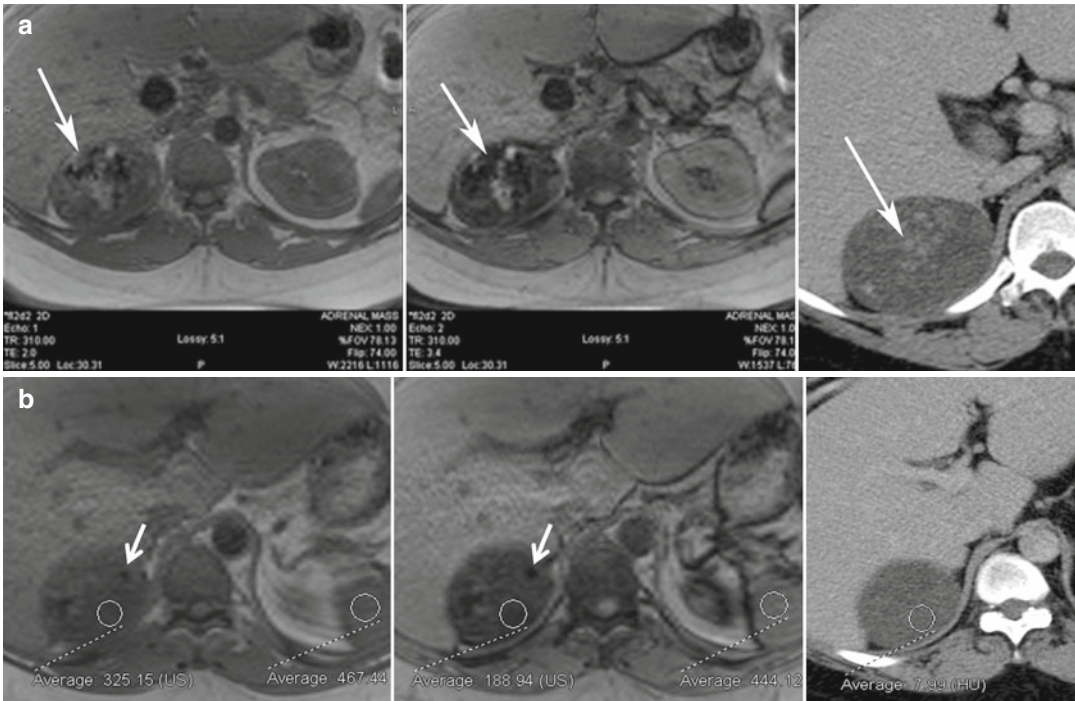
Thirty-four-year-old man with proven adrenal cortical carcinoma following resection. (a) Axial in-phase (TE=2.0 ms) and opposed-phase (TE=3.4 ms) gradient-echo (GRE) MR images show the potential pitfall of chemical shift imaging at 3 T. When the opposed-phase image is compared to the in-phase image, there is a large area of decreased signal intensity (*white arrow*) related to calcifications within the tumor from T2* effects, which is confirmed in the axial CECT image. Another focus of calcification is noted in a separate portion of the mass (*white arrow*) with blooming artifact from T2* effects. When opposed-phase images are performed at a longer TE, drop in signal can be related to lipid or susceptibility artifact. (b) Other areas
